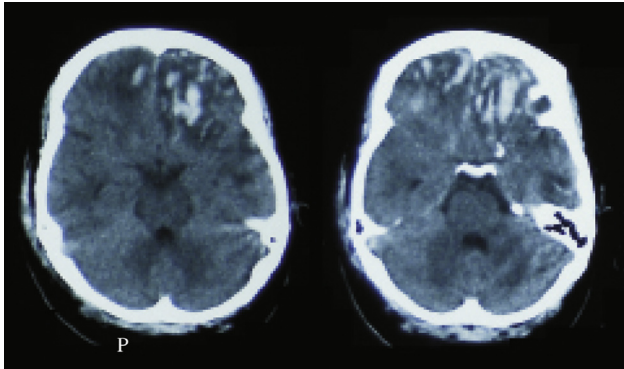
Repeated CT brain showing progression of bilateral frontal contusion.
